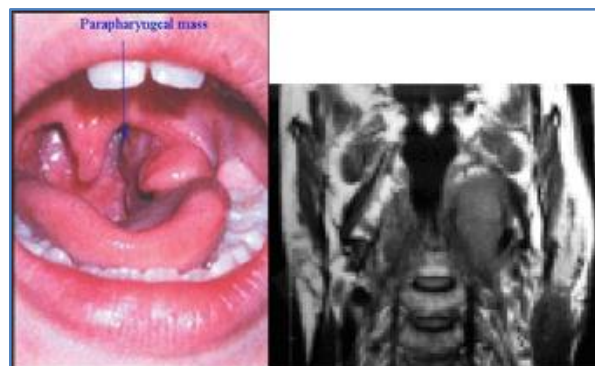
Showing the pre-operative picture and its CT scan of Parapharyngeal tumor (Tumor pushing the left Tonsil)
